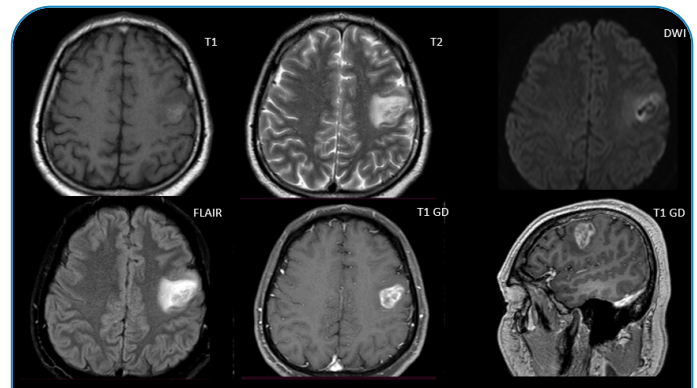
First MRI. Left to right, top to bottom, brain MRI sequences of axial slices in unenhanced T1, T2, diffusion, FLAIR, T1 with contrast, and sagittal T1 with contrast, respectively. Lesions pointed by blue arrows.
